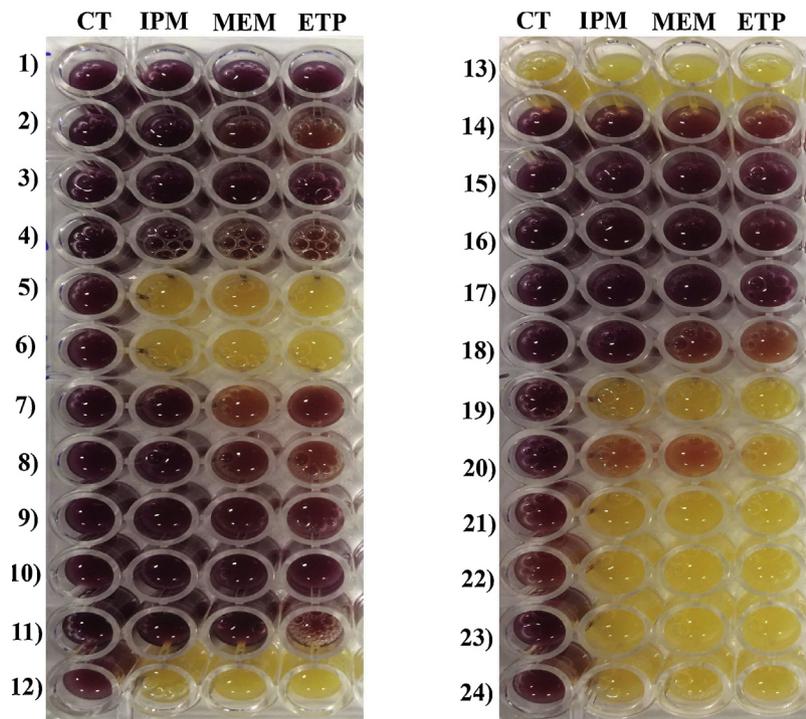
Representative results from the Nitro-Carba test. CT, control (water); IPM, imipenem (200 $\mu\text{g/mL}$); MEM, meropenem (50 $\mu\text{g/mL}$); ETP, ertapenem (20 $\mu\text{g/mL}$). Row 1, VIM-1 + SHV-12-producing *Klebsiella pneumoniae* 4034; row 2, OXA-48-producing *K. pneumoniae* 4026; row 3, VIM-1 + SHV-102-producing *K. pneumoniae* 4033; row 4, OXA-48-producing *K. pneumoniae* 4012; row 5, DHA-1-producing *Escherichia coli* 2003; row 6, CTX-M-9 + ACT-18-producing *E. coli* 3003; row 7, OXA-48-producing *Enterobacter cloacae* 4003; row 8, OXA-48-producing *E. coli* 4010; row 9, NDM-1-producing *E. cloacae* 4004; row 10, KPC-3-producing *E. coli* 4006; row 11, KPC-2-producing *Klebsiella oxytoca* 4032; row 12, CTX-M-3 + ACT-1-producing *Citrobacter freundii* 3005; row 13, non- β -lactamase-producing *E. coli* ATCC 25922; row 14, NDM-1-producing *E. coli* 4011; row 15, KPC-3-producing *K. pneumoniae* 4014; row 16, KPC-producing *K. pneumoniae* 4018; row 17, OXA-48-producing *E. coli* 4007; row 18, OXA-48-producing *K. pneumoniae* 4021; row 19, DHA-1-producing *K. pneumoniae* 2001; row 20, DHA-1-producing *E. coli* 2002; row 21, CTX-M-15 + SHV-27-producing *K. pneumoniae* 1010; row 22, SHV-12 + CTX-M-9 + ACT-32-producing *E. aerogenes* 3002; row 23, ACT-32-producing *E. cloacae* 2009; and row 24, CTX-M-15-producing *E. coli* NCTC 13353.
